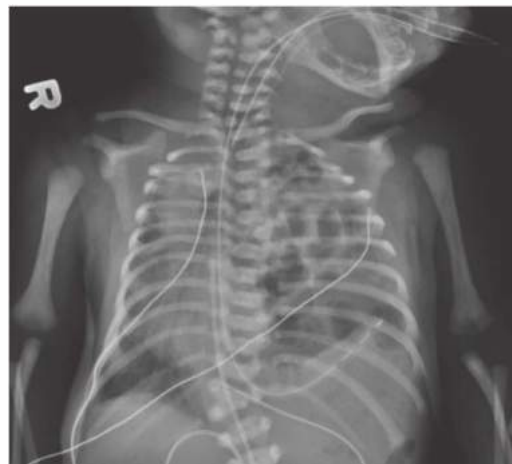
• Chest x-ray in neonate demonstrating a left CDH. Note that the stomach and liver are both transposed into the left chest and the mediastinum is shifted to the right.
